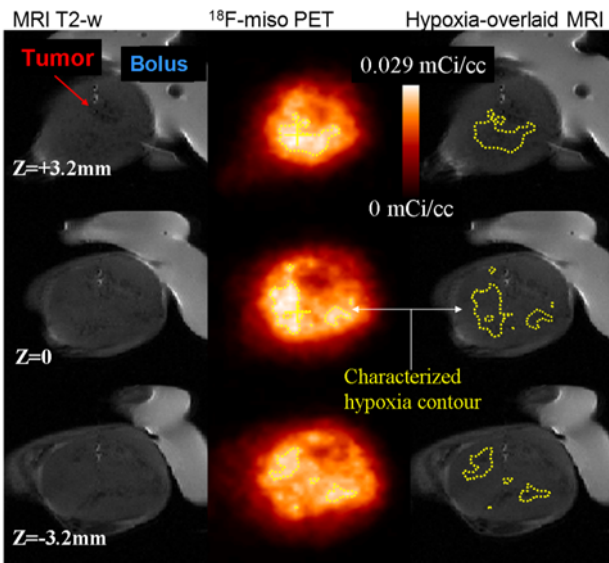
Registration of MRI T2-weighted and ^{18}F -miso PET images of three transverse slices of a 4T1 tumor. The hypoxic areas characterized by contours of tumor/muscle (T/M) ratio >1.2 . The water bolus used is shown in the MRI T2-weighted images but not in the PET images.
